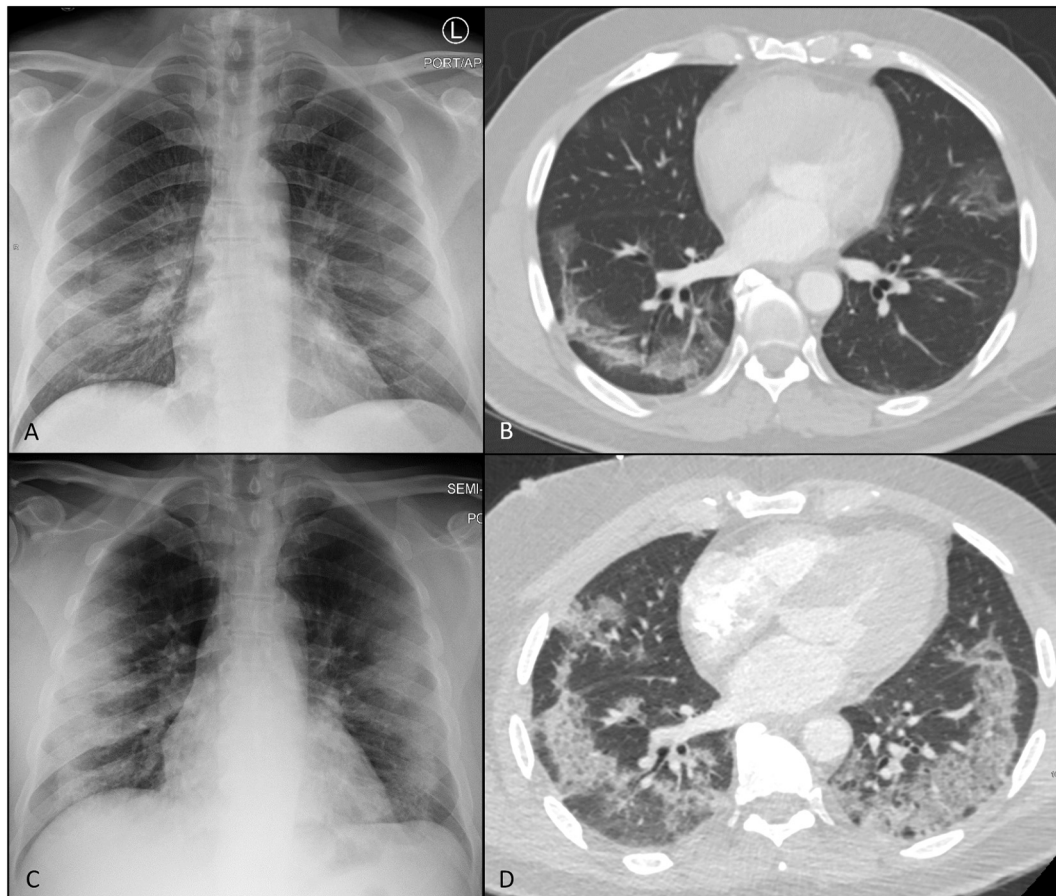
Baseline CXR (A) demonstrates GGO involving mainly the lower zones and was assigned CoV-P1 by both observers. Lower lungs seen on CT abdomen/pelvis (B), that was ordered for diarrhea and abdominal pain, demonstrates bilateral GGO. CXR on emergency re-visit for mild respiratory symptoms (C) demonstrates interval development of bilateral areas of consolidation, mainly peripherally, involving predominantly 4 zones and was assigned CoV-P2 by both observers. CTPA for clinical suspicion of pulmonary embolism (D) demonstrates interval development of crazy-paving with increased extension of the disease, however was negative for pulmonary embolism. The patient deteriorated into a critical status 3 days following CoV-P2 CXR.
